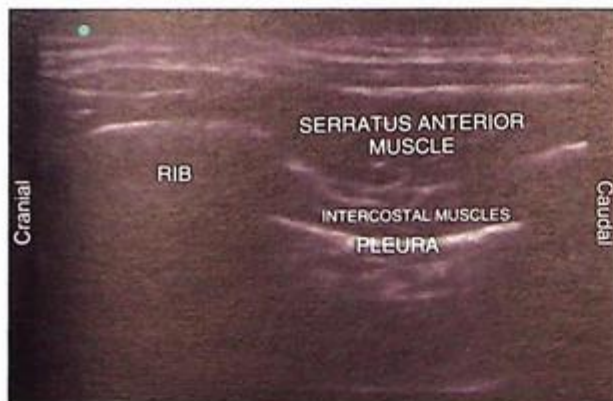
Ultrasound image of the serratus anterior block, showing the serratus anterior and intercostal muscles. It is very important to visualize the pleura when performing the block, as shown in the figure.
